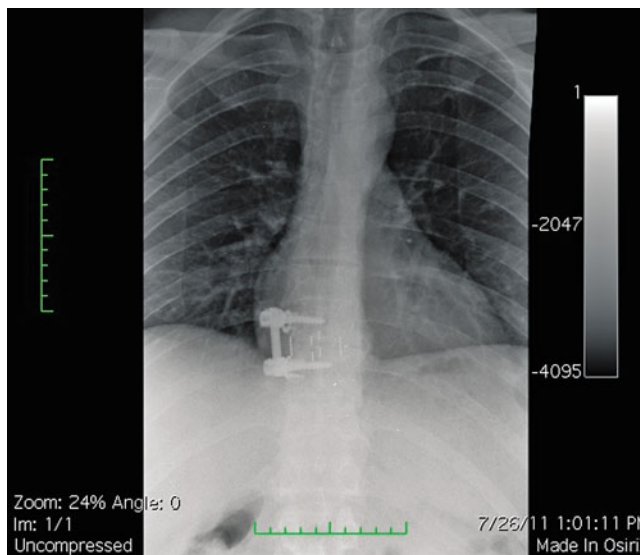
Postoperative x-ray demonstrating spinal instrumentation with lateral cage and vertebral screws and rod
